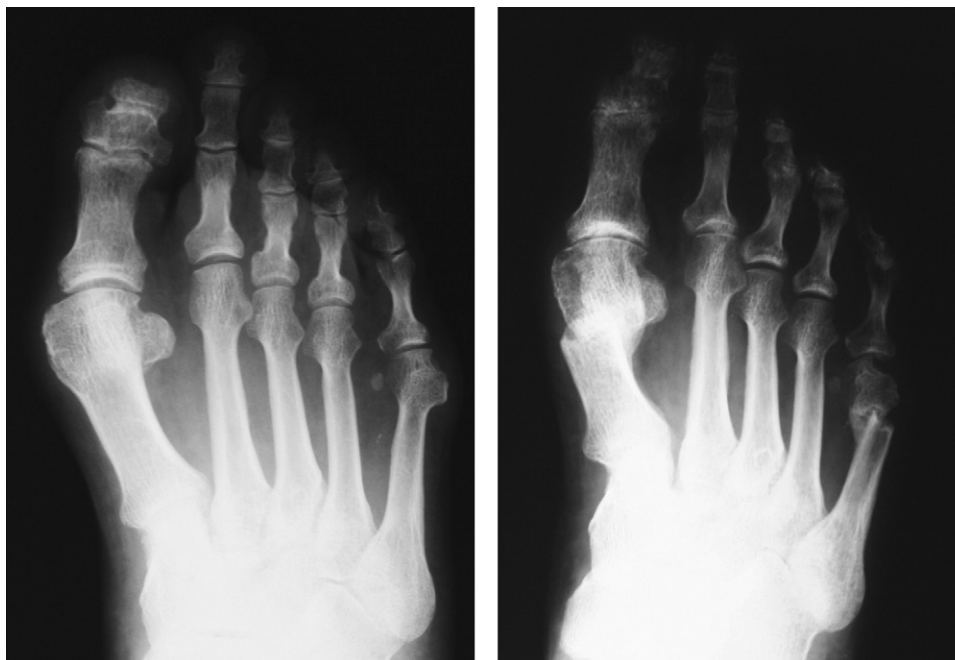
A male patient aged 58: radiographs of pre-op and follow-up at 3 months.
